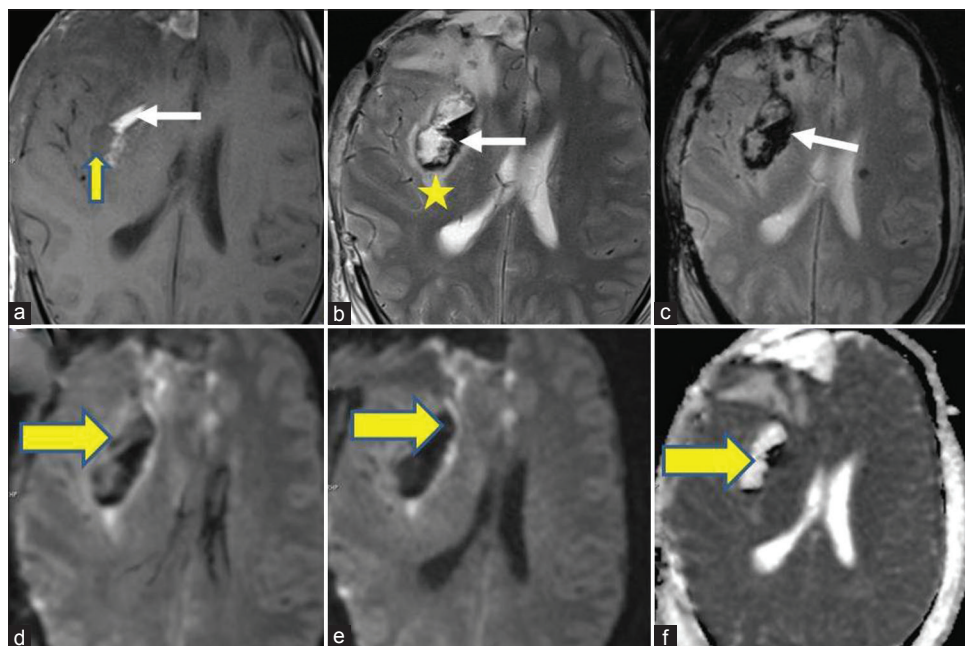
Case 1: Magnetic resonance imaging done on 2nd postoperative day showing lesion around (broad arrow) right sylvian fissure. (a) T1-weighted image showing isointense lesion abutting insular cortex (thin yellow arrow). (b) T1-weighted image showing hyperintense lesion with hypointense rim on lateral aspect. Surrounding hyperintense edema (star) was present. (c) Flash image showing blooming on medial aspect of the lesion (white arrow) representing bleed. (d-f) B500 and B1000 image showing no diffusion restriction (yellow arrow)
